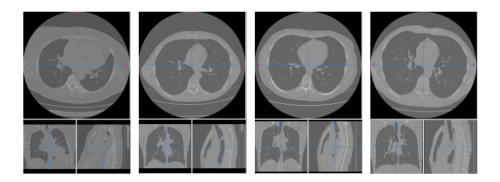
ImageCLEF2017 dataset for lung CT images
